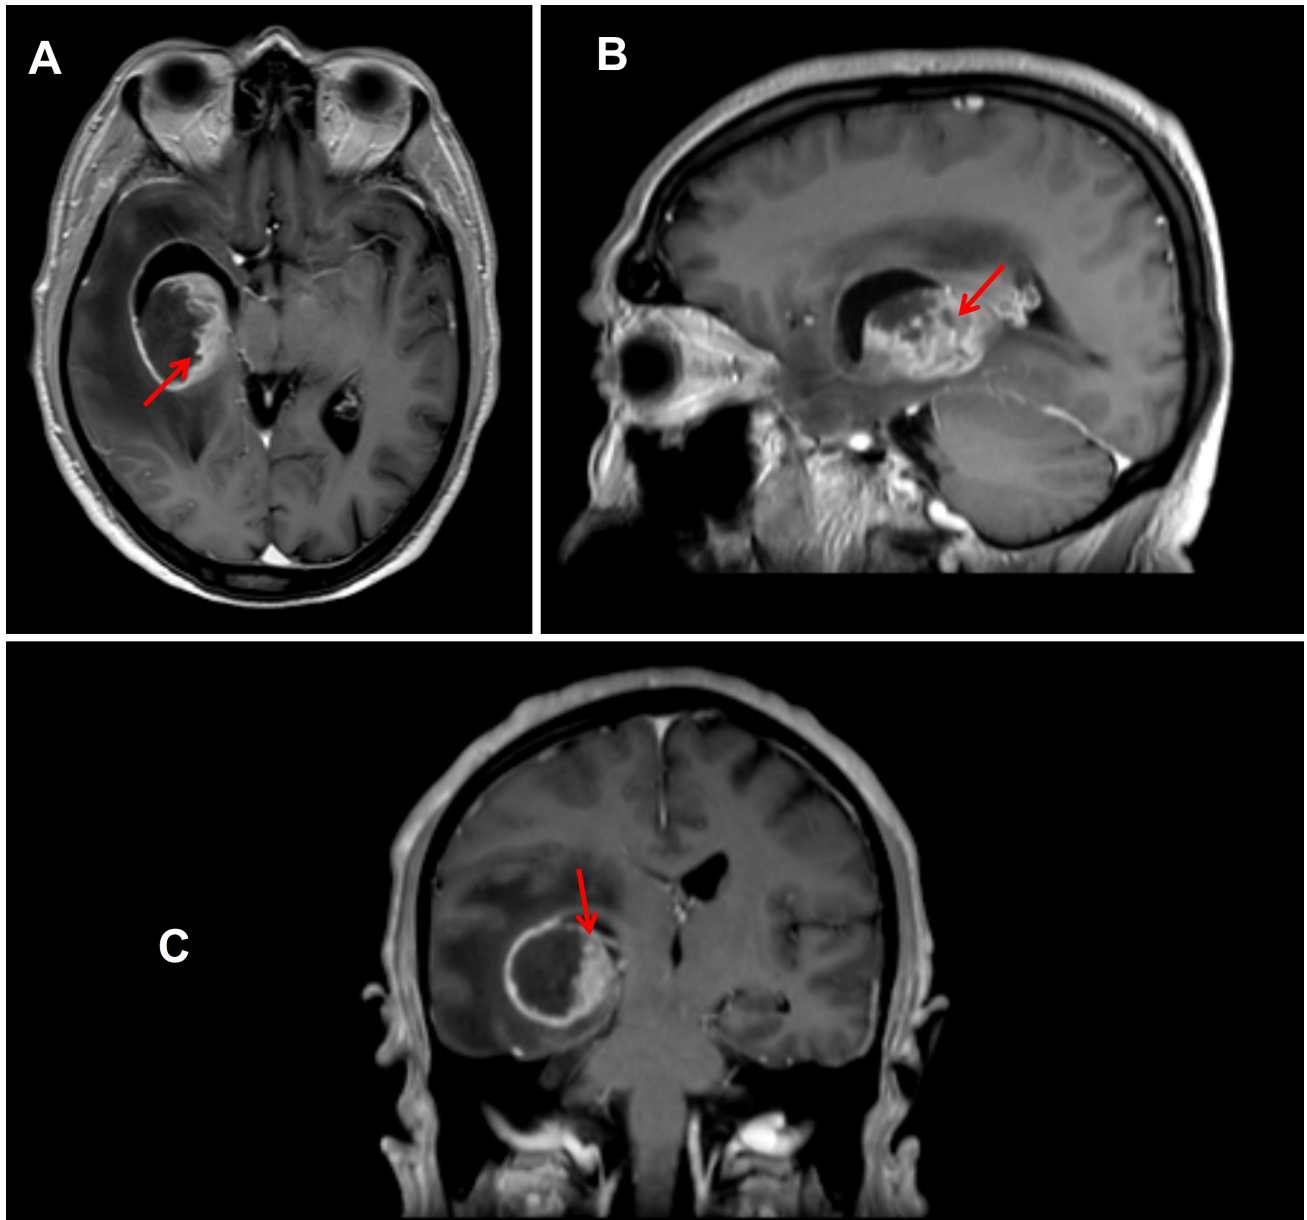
Magnetic resonance imaging (MRI) brain images with gadolinium contrast demonstrate a voluminous intra-axial lesion centered within the deep right temporal lobe. The lesion exhibits heterogeneous signal intensity on T1-weighted (A) axial, (B) sagittal, and (C) coronal sequences. Surrounding the lesion is a hyperintense signal indicative of vasogenic edema. Post-contrast administration reveals significant enhancement of the lesion, particularly in the medial aspect (red arrows), with a lateral component showing hypointense signal suggestive of reduced contrast enhancement. Anteriorly and superiorly within the lesion, a fluid-cystic component is noted, displaying thin peripheral enhancement on post-contrast imaging. This image is from Garibaldi Hospital, Catania, Italy, and informed consent was obtained from the patient for this study.
